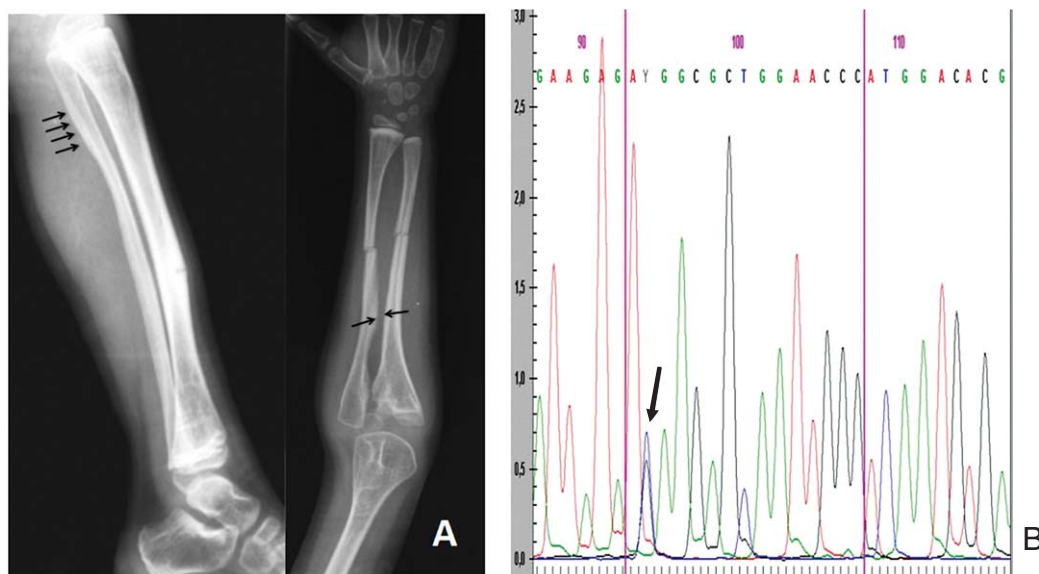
(A) Radiographs of the patient's limbs showing fractures and interosseous membrane calcifications development as well as the initial evidence of periosteal calcification (arrows). Radial head dislocation is visible on the forearm anteroposterior view. (B) Sequence of patient's genomic DNA obtained from leukocytes showing C/T heterozygosity at -14 nt within the 5'UTR region of *IFITM5*.
